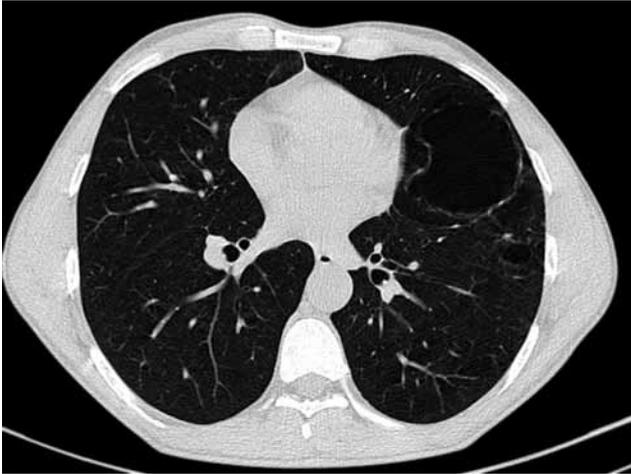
Chest computed tomography of patient revealed an air cyst located in lingular segment.
